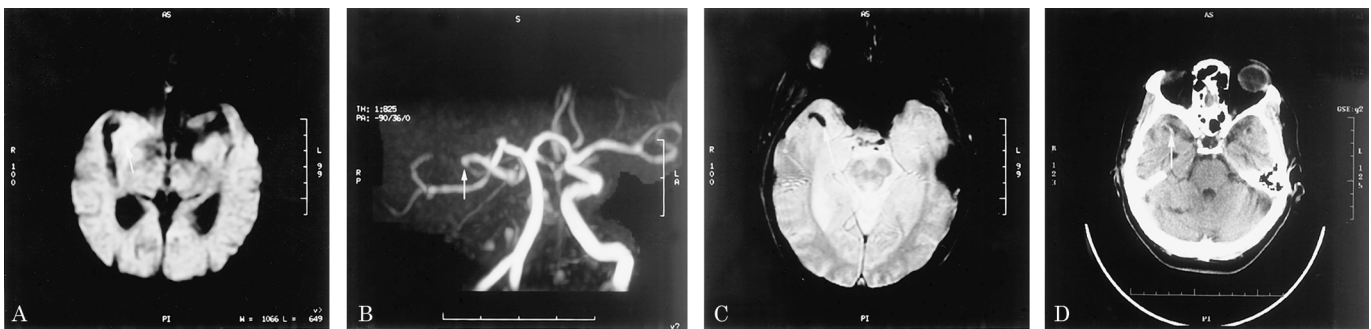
(A) Hyperintense region is seen in the right middle cerebral artery (MCA) territory on diffusion-weighted imaging compatible with an acute infarct (arrow). (B) MR angiography shows occlusion of the right internal carotid artery with partial cross-filling of the right MCA and signal loss at the right M1 segment (arrow). (C) GRE reveals the susceptibility artifact of acute thromboembolism in the right MCA (arrow). (D) Nonenhanced CT depicts a right hyperdense MCA sign (arrow).
